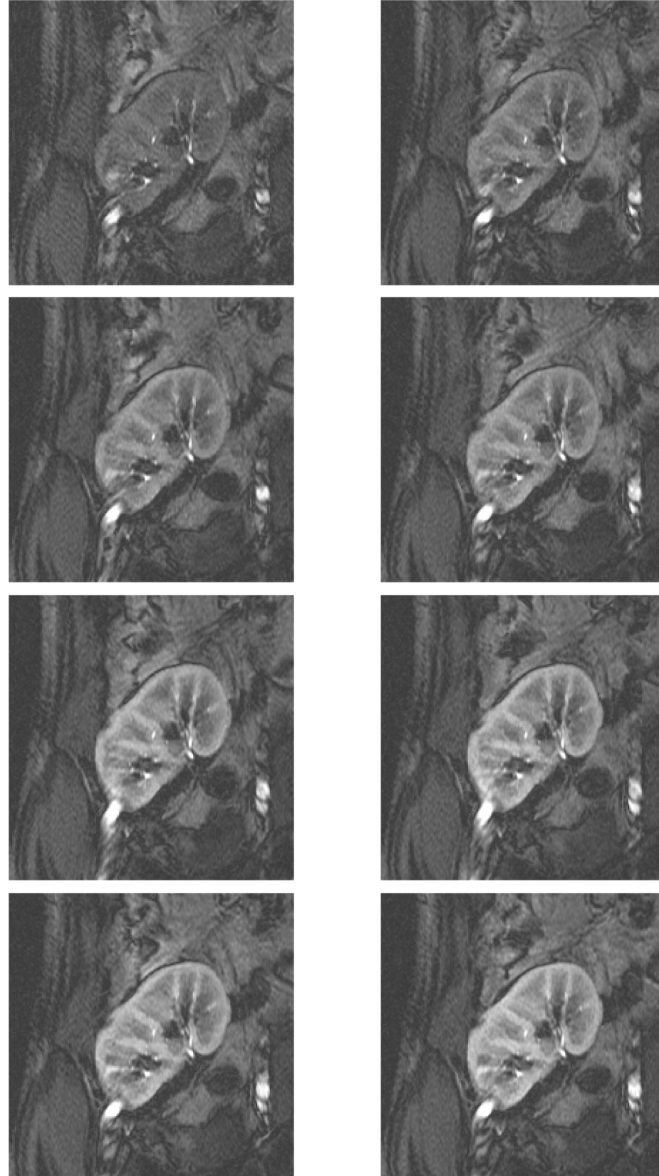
Example of a DCE-MRI series. For each patient, 150 images are taken from one cross-section with 4-second intervals. Eight of one subject (numbers 1, 4, 5, 6, 10, 15, 21, 27) are shown here to give an idea of the protocol.
